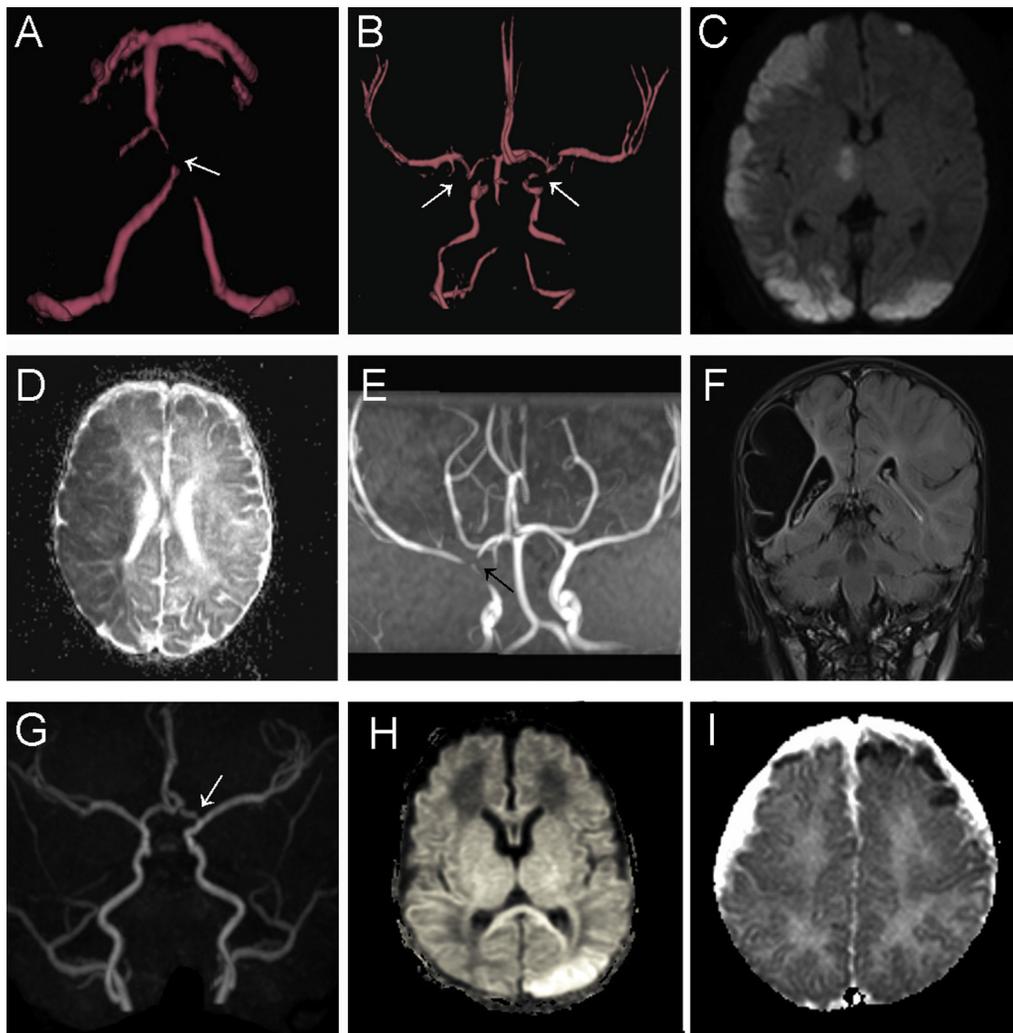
Examples of neuroimaging findings found in the study cases. A and B, On the 3-dimensional time of flight MR angiography severe stenosis of the A, basilar artery (*arrows*) and B, both terminal internal carotid arteries can be seen (*arrows*). C, Multifocal superficial cortical infarction with diffusion restriction on the diffusion weighted images. In addition, there is ischemic infarction involving the right thalamus. D, Apparent diffusion coefficient maps showing an acute ischemic lesion involving the complete MCA stroke territory. E and F, MR angiography reveals a severe stenosis and reduced flow within the right distal internal carotid artery and the proximal MCA (*arrow*) of the same patient. F, On follow-up 3 months later MRI shows encephalomalacia in the former stroke area. G, MR angiography reveals a stenosis of the A1 segment of the anterior cerebral artery. H, Ischemic infarct involving left posterior, inferior temporal, and occipital lobe. Additional involvement of the splenium of the corpus callosum. I, Left more than right frontal, superficial infarction (apparent diffusion coefficient maps).
